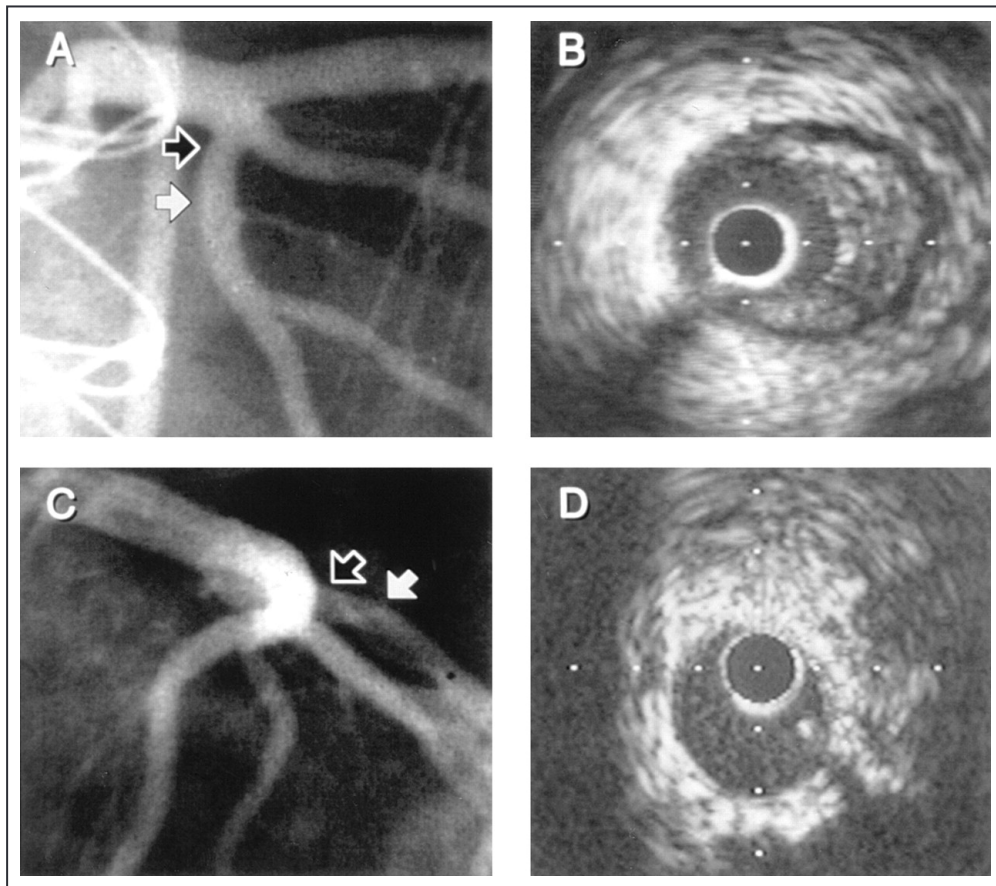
A, Arteriogram of the left coronary artery in the right anterior oblique projection. Black arrow indicates imaging site shown in B; white arrow, imaging site shown in D. B, intravascular ultrasound image of the proximal circumflex artery. Despite a large eccentric plaque, a large circular lumen similar to that in D is preserved because of remodeling. C, Left coronary angiogram in the left anterior oblique projection. Black arrow indicates imaging site shown in B; white arrow, imaging site of proximal circumflex artery shown in D. D, intravascular ultrasound image at another site in the proximal circumflex artery showing normal arterial morphology.
